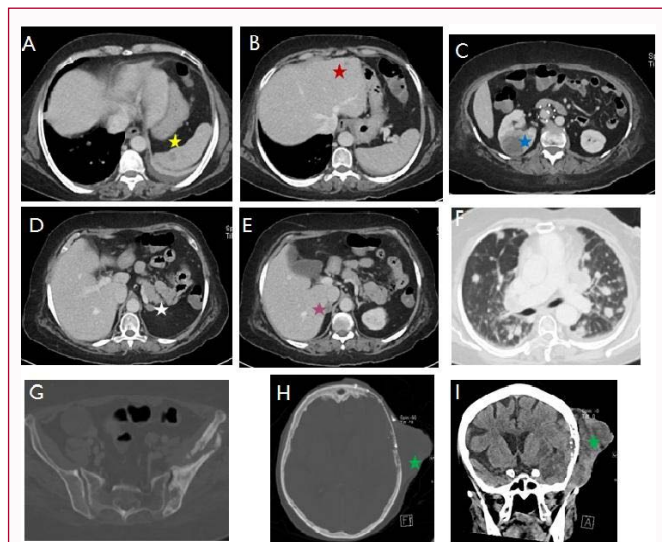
The follow-up CT of the brain, chest abdomen and pelvis: A, B, C, D and E) Axial images of the abdomen showed new focal hypodense splenic lesion measuring 0.9 cm x 1 cm (yellow star), new small focal small hypodense lesions at segment II measuring 0.7 cm (red star), the right kidney interpolar cortex mass measuring 3.5 cm x 3.1 cm (blue star), bilateral hypodense adrenal lesions, within the left adrenal measures about 1.3 cm x 1.1 cm (white star), the largest on the right side measures 1.5 cm x 1.3 cm (purple star). F) The axial images of the lung showed significant interval worsening of bilateral lung metastasis with hilar lymphadenopathy and minimal bilateral pleural effusions, left more than right. G) The axial images of the pelvis, bone window, showed interval progression complicated with fracture in the left iliac lytic lesion. H and I) the axial and the coronal images of the CT of brain showed interval significant progression of the previously seen left temporal extracranial lobulated soft tissue.
